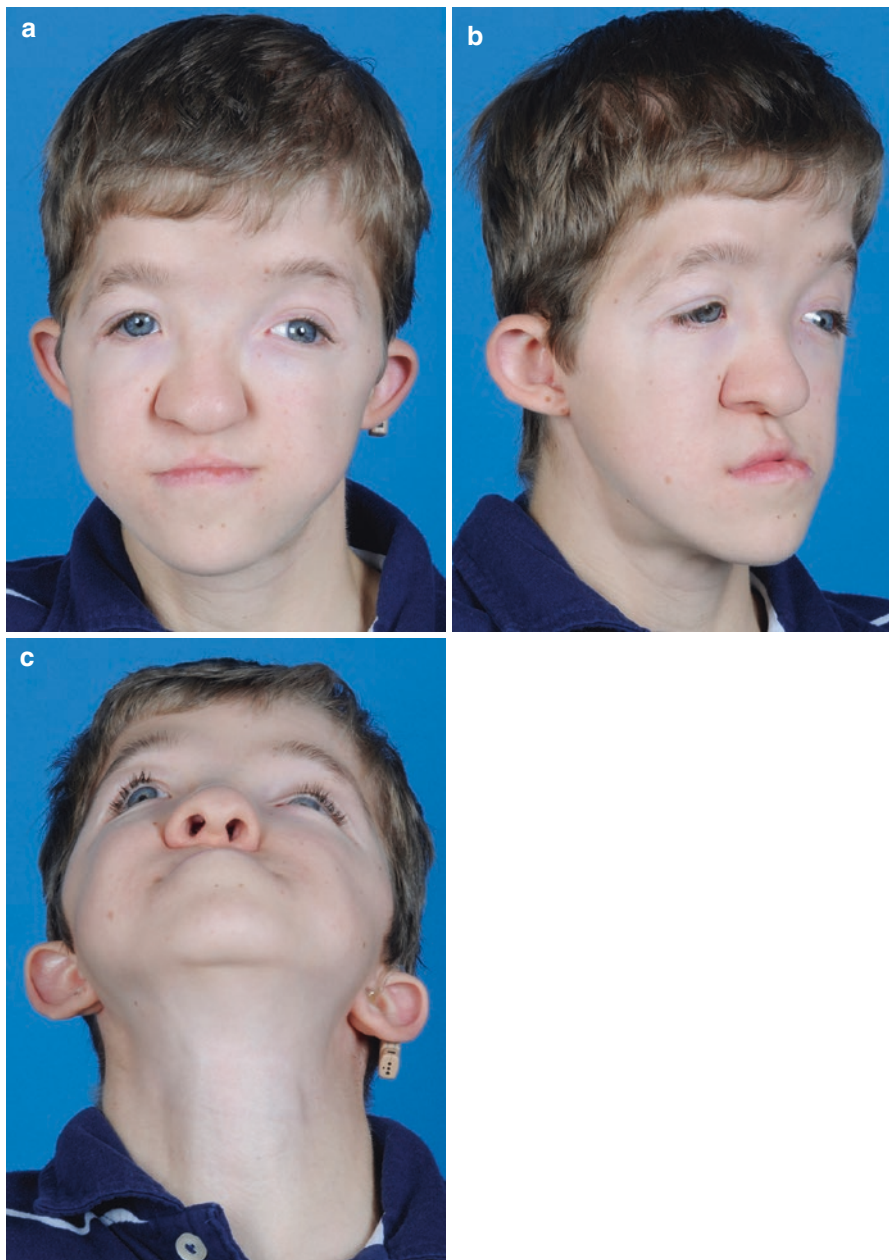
In a primary procedure, the areas of fibrous union in the orbitozygomatic areas were resected and bone grafted after skeletal repositioning. (a–c) Patient appearance following this procedure. (d–f) Corresponding CT images
